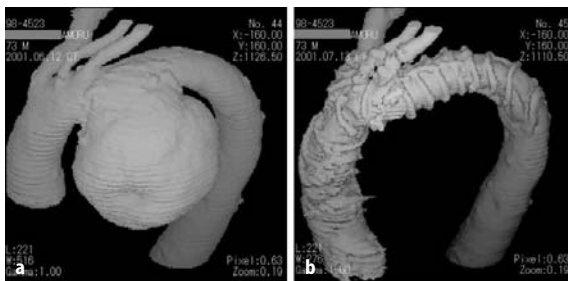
Triple-branched stent-graft for treatment of aortic arch aneurysm. a Computed tomography (CT) image demonstrates a huge transverse aortic arch aneurysm. b CT image obtained after stent-graft placement shows complete exclusion of the aneurysm
